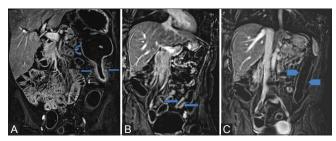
(A-C): (A) Coronal postcontrast fat-suppressed three-dimensional T1-weighted image showing a featureless segment of mid descending colon with wall thickening and enhancement (arrows) and mild upstream dilation (curved arrows), suggesting stricturing. Note the mesenteric vascular engorgement consistent with "comb sign." (B, C) Contiguous coronal postcontrast fat suppressed three-dimensional T1-weighted images showing early post contrast enhancement within the distal descending colon (arrows in C) with a mildly dilated featureless proximal descending colon (arrowheads in C), consistent with lead pipe colon
